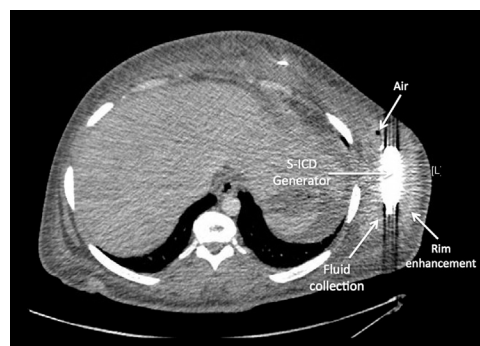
Computed tomographic scan of the chest showing device pocket infection. A rim-enhancing fluid collection (11.4 × 5.1 × 10.1 cm) surrounding the subcutaneous implantable cardioverter-defibrillator generator is shown. A small pocket of air within the fluid collection is also shown. S-ICD = subcutaneous implantable cardioverter-defibrillator.
